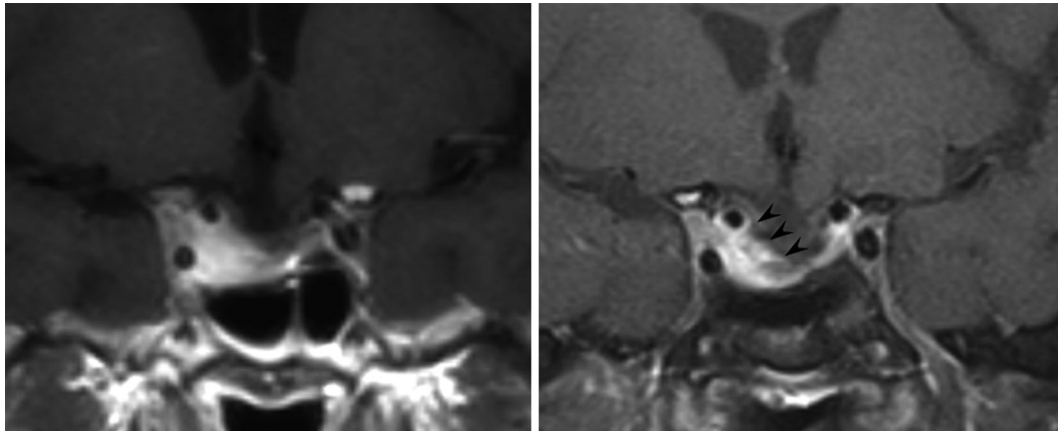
Contrast enhanced T1-weighted MRI images of Patient #5 showing the pituitary adenoma shrinkage (arrowheads) from 3,632 mm³ at baseline to 2,875 mm³ after 6 months of Pasireotide + TMZ combined treatment (volume reduction of 21 %)
